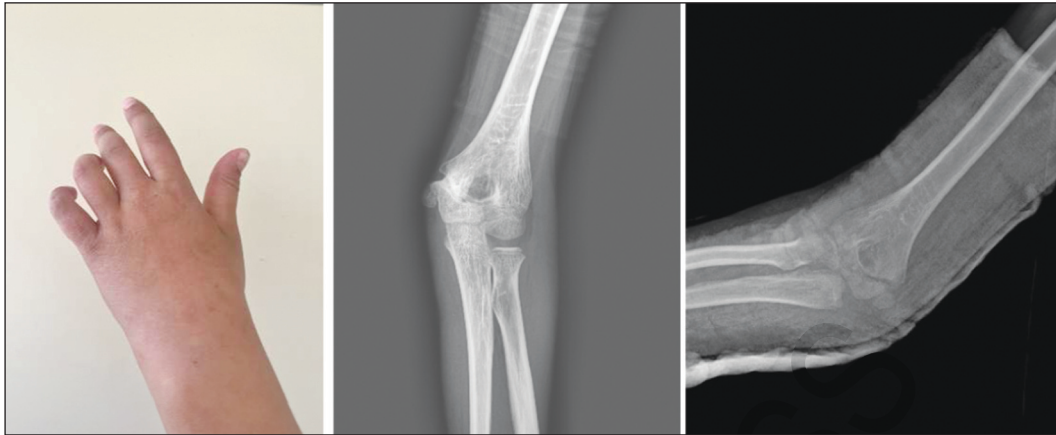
A) Claw-hand deformity at presentation. B) Anteroposterior X-ray of the elbow shows minimally displaced medial condyle fracture of the humerus. C) Anteroposterior X-ray of the elbow shows union of medial condyle fracture of the humerus and a medial spike on the metaphysis
